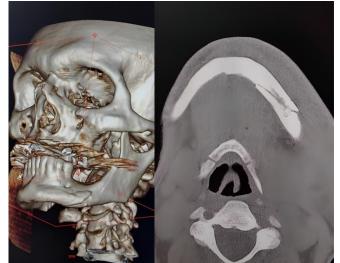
Computed Tomography. Source: The authors, 2023.
